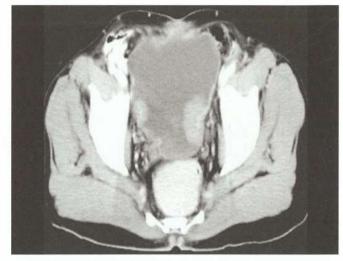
Contrast CT of the bladder showing filling defects in two places suggestive of carcinoma bladder
